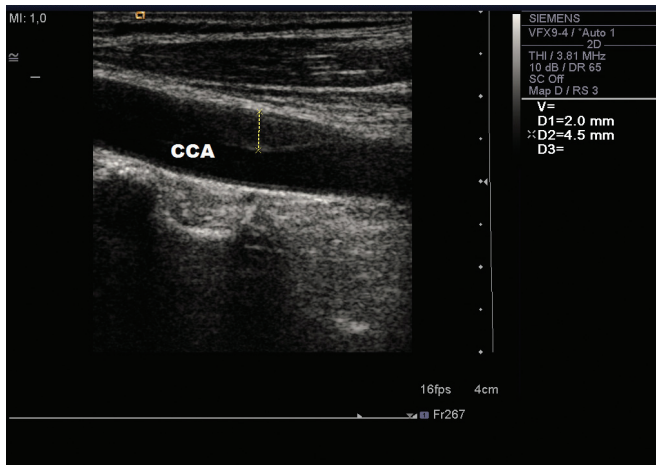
Carotid artery intima-media thickness measured by B-mode ultrasonography. CCA indicates common carotid artery.
